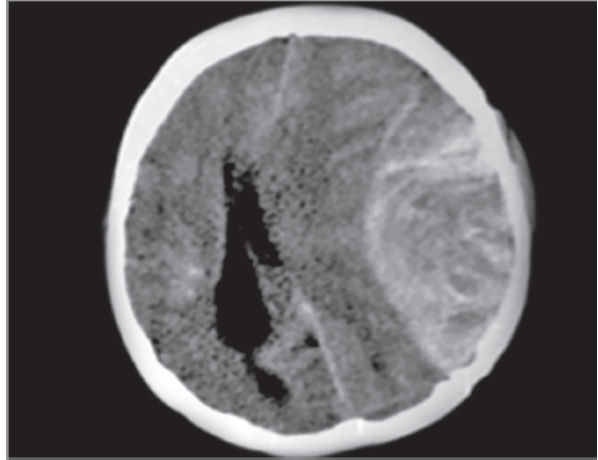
Plain CT head showing hyperdense shadow which is biconvex in appearance suggestive of acute left extradural hematoma.
